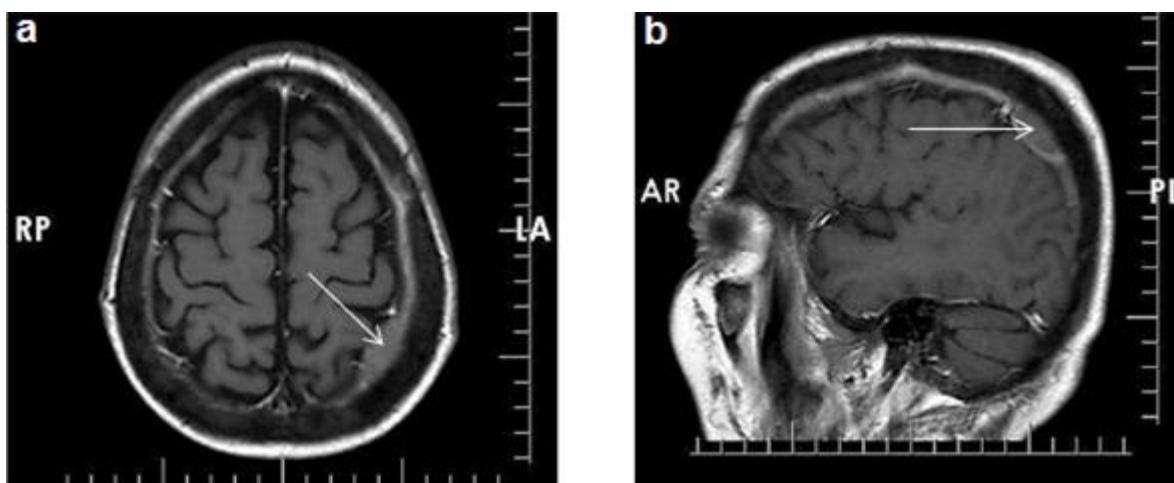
Mass lesion in the left parietal region, which formed a wide base with the dura mater and had a dural thickening with a contrast agent uptake in the post-contrast T1A axial and sagittal MRI respectively. The white arrows indicate dural thickening (a) and (b).
